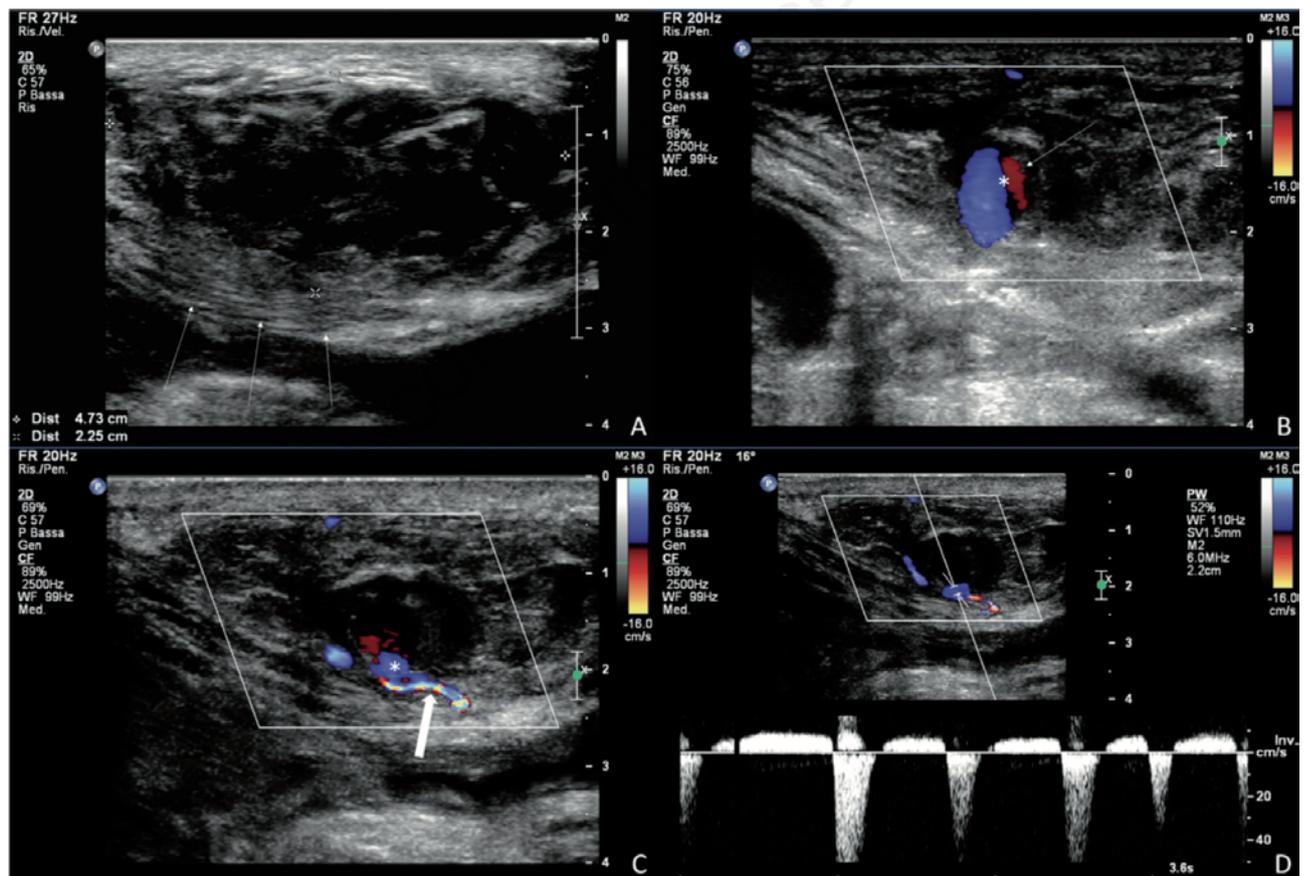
Ultrasound (US) examination with a 5-12 MHz linear probe (iu22, Philips Healthcare, Amsterdam, Netherlands) of the abdominal wall of a 77 years-old lady presenting with swelling at the right iliac fossa. A) B-mode US obtained at the swelling site demonstrates a 4.73×2.25 mm heterogeneous mass (dimension markers) in the right rectus abdominis muscle (arrows), which appear to be stretched by the mass. B) Color-Doppler US demonstrates a “yin-yang” sign (*) on the inside of an anechoic round structure (arrow, B-mode not showed) within the heterogeneous mass, consistent with a pseudoaneurysm surrounded by hematoma. C) Color-Doppler US demonstrates the adjoining arterial vessel (thick arrow) and the neck (*) of the pseudoaneurysm. D) Pulsed-Doppler at the pseudoaneurysm neck level demonstrates the classic “to and fro” pattern.
